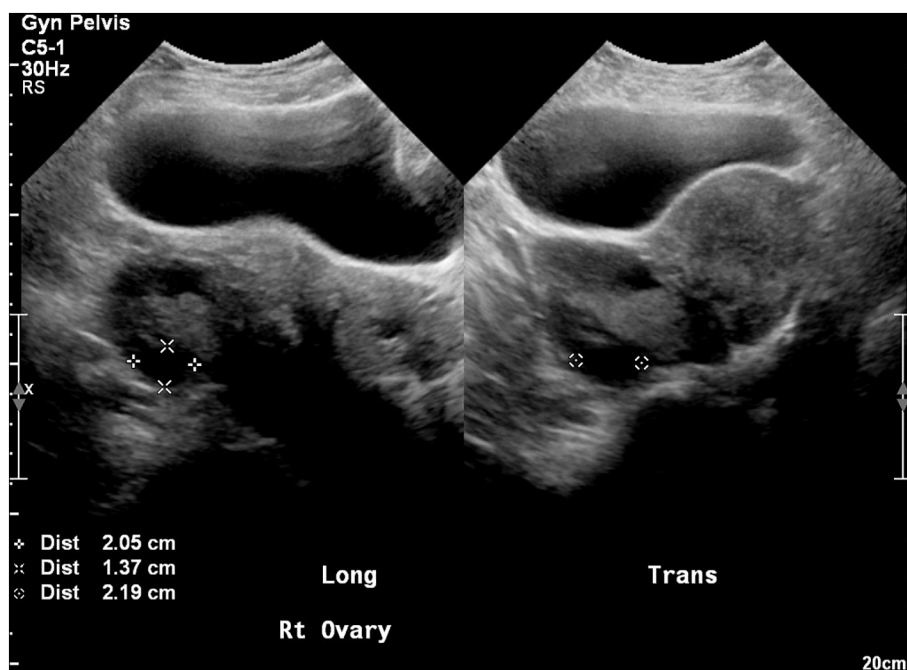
Preoperative Pelvic Ultrasound Right Ovary.
